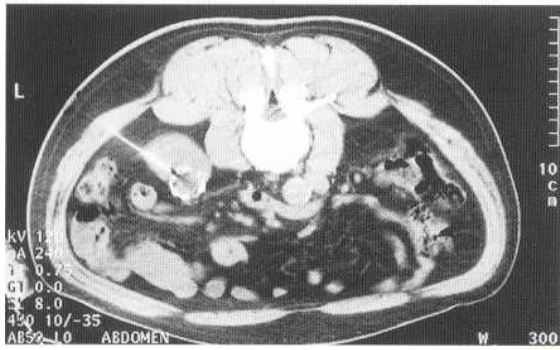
Percutaneous cyst aspiration. A 22 gauge needle has been positioned within a heavily calcified cyst under CT guidance for diagnostic aspiration.
